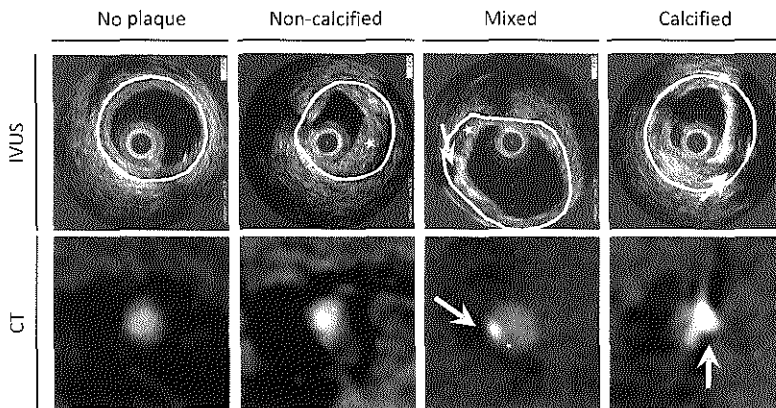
Example of co-registered Intravascular Ultrasound (IVUS) and Dual-Source Computed Tomography (CT) images for absence of plaque, and for presence of non-calcified, mixed and calcified plaque. The arrows indicate calcium and the stars (*) are placed in the non-calcified part of the plaque
